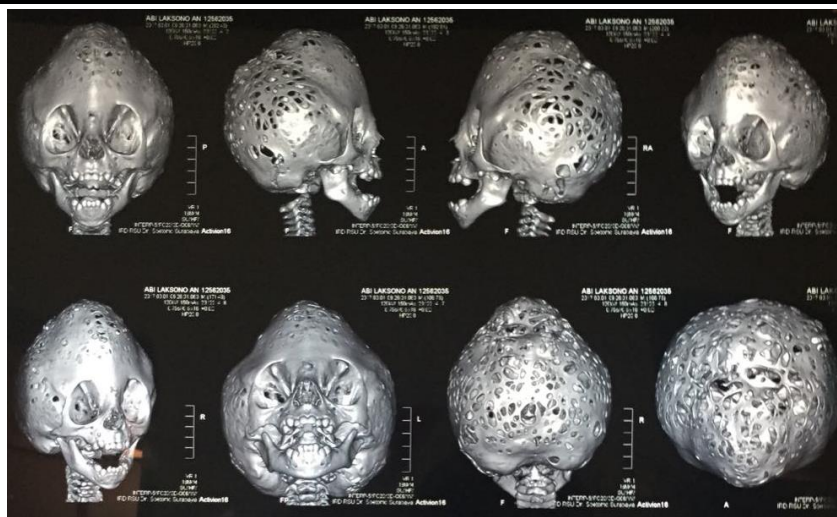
Head CT-scan, March 2017
